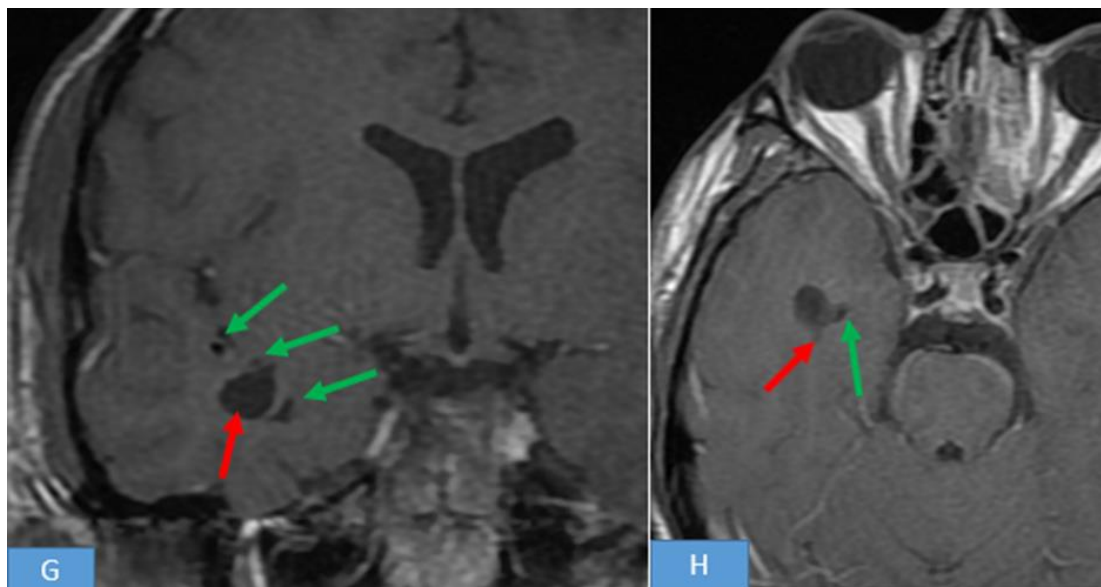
Brain MRI: T1 Coronal (G) and axial (H) sequences after Gadolinium injection: Other small lesions (Green arrows) adjacent to the first one (Red arrow), with similar characteristics
